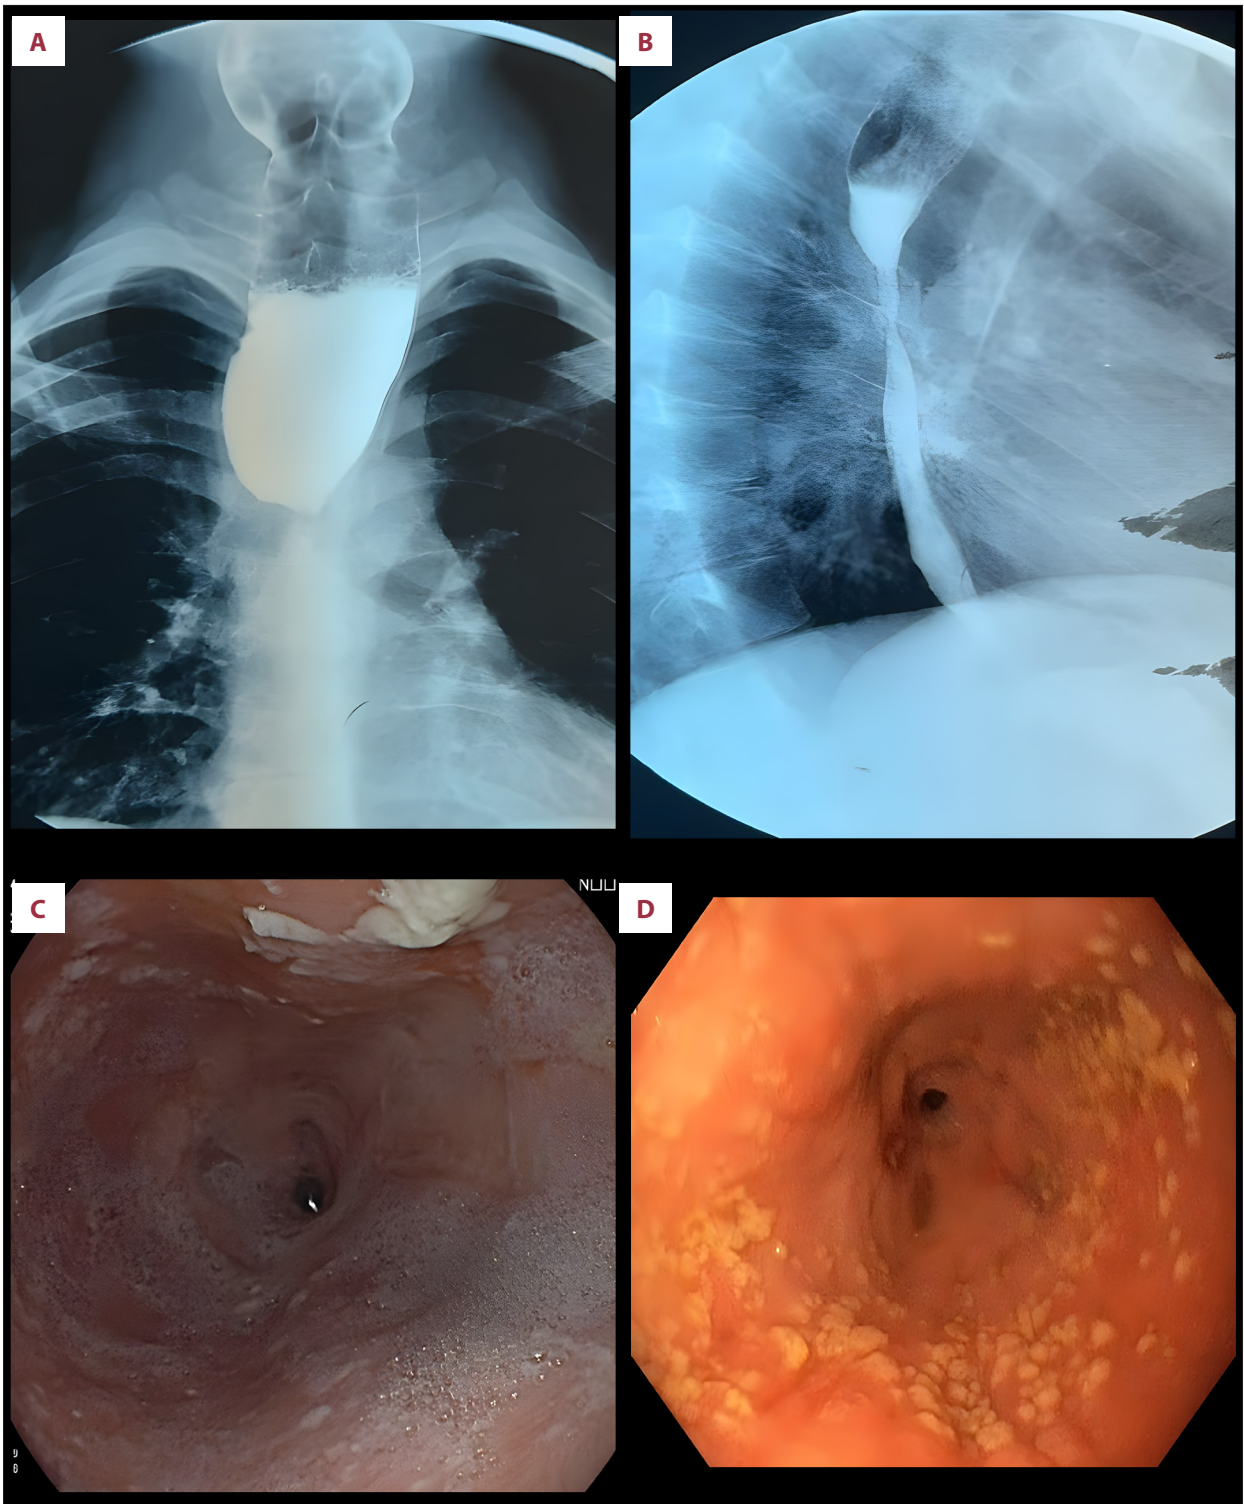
Contrast esophagography with barium sulfate. (A) Anteroposterior radiograph showing an elongated stricture in the middle to lower thoracic esophagus. (B) Lateral radiograph demonstrating the elongated stricture in the middle to lower thoracic esophagus. (C) Endoscopic image showing cicatricial stenosis that involves the middle third of the esophagus, with a luminal diameter of approximately 0.3 cm. (D) Endoscopic image demonstrating severe cicatricial stenosis approximately 30 cm from the incisors, preventing passage of the gastroscope.
